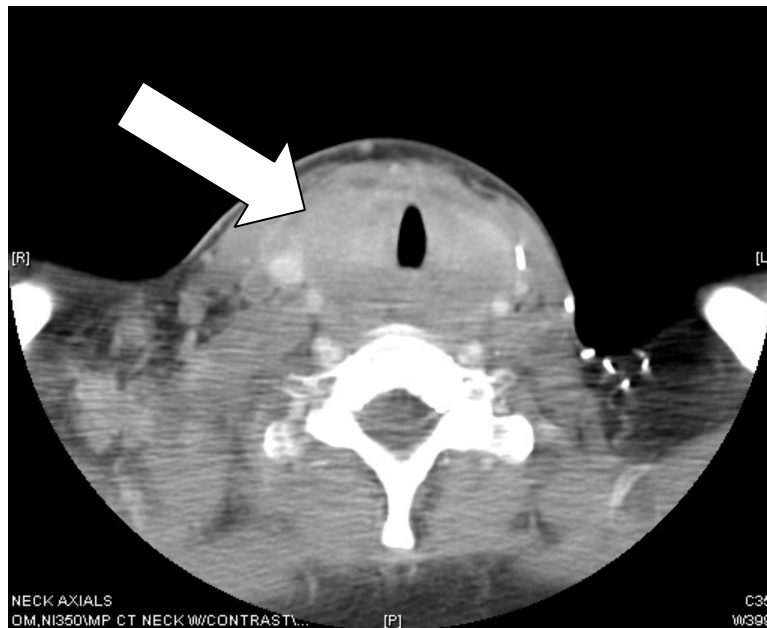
CT Scan of the Neck with contrast
